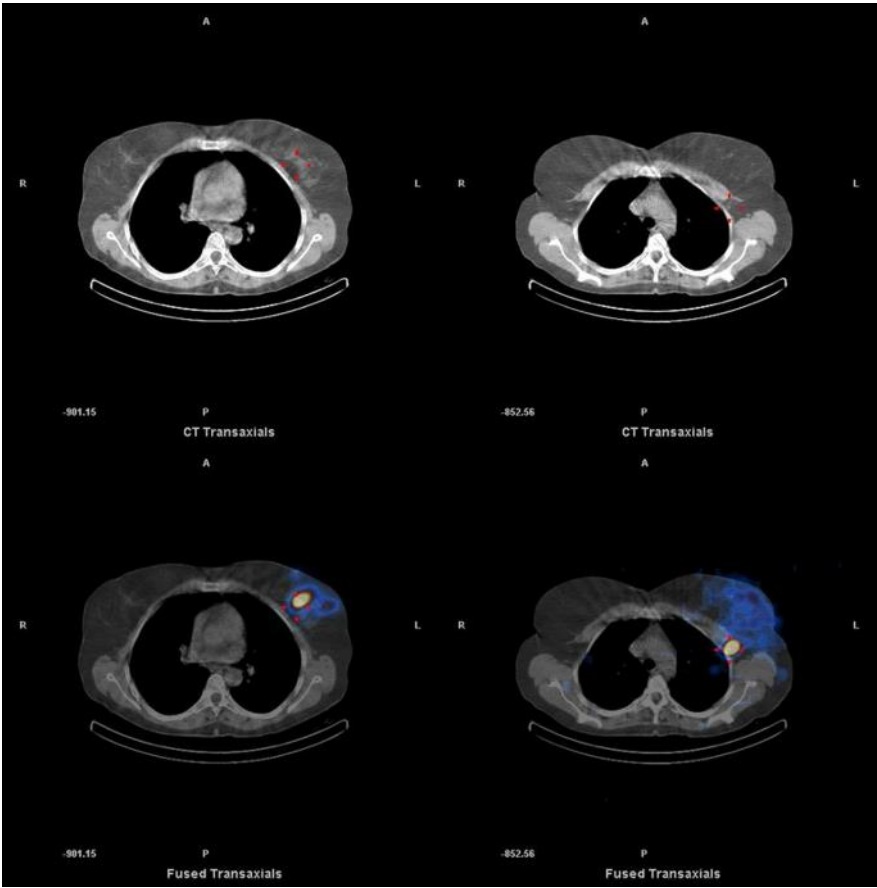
Axial CT and fused SPECT/CT images revealed the left breast lesion as well as the axillary sentinel lymph node.
